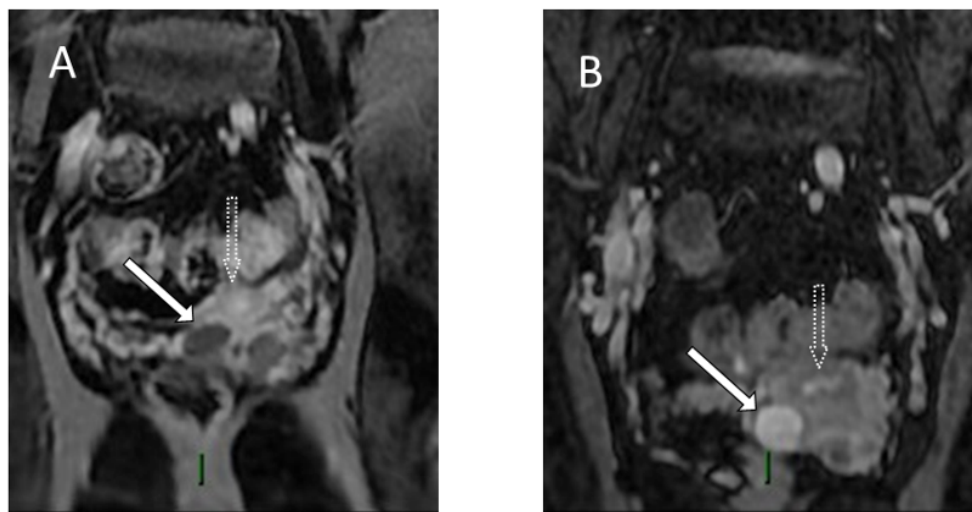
Patient MRI with PMDS. Coronal views shows the endometrial cavity of the uterus (dotted arrows), which are normally enhanced in Figure 1A (T1 post-contrast imagine) and normally hyperintense in Figure 1B (T2 image). The infero-lateral right ovoidal mass corresponds to the testis (white arrows).
